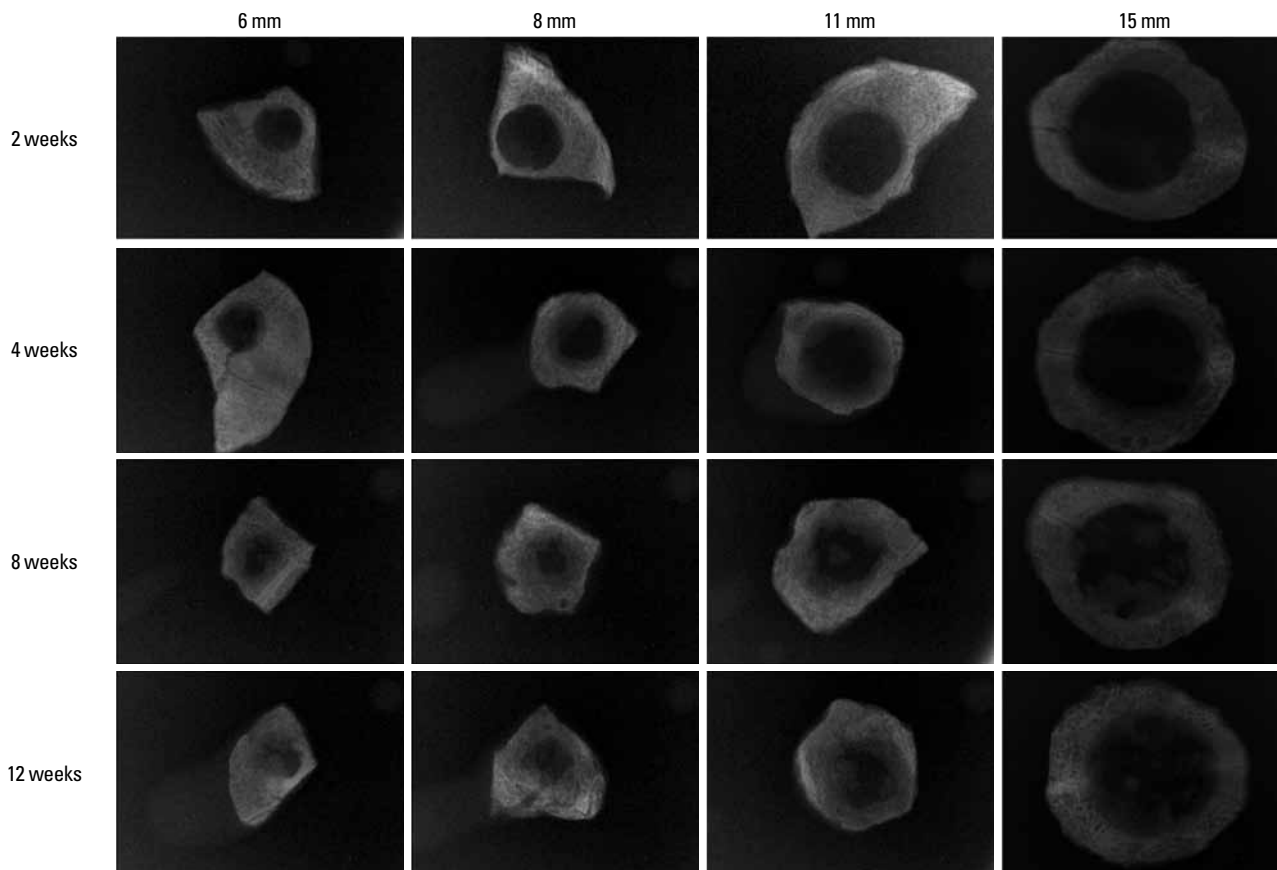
Radiographic views of the surgical defects at different healing periods.
